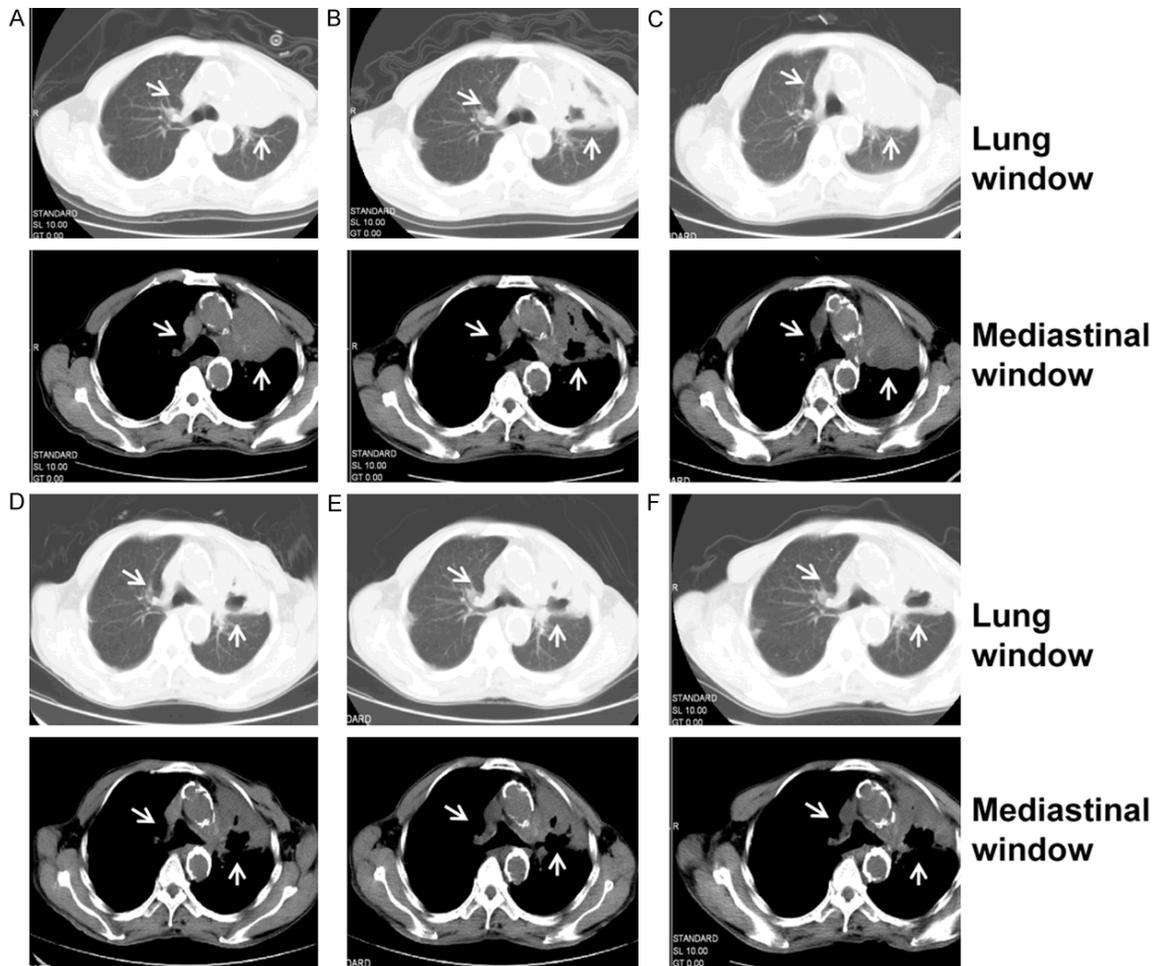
CT scans. (A) Baseline CT images revealed multiple lymph node metastases around the region of aorticopulmonary window and left hilar. (B) CT scan showed partial response after everolimus treatment for one month. (C) CT scan showed progressive disease after everolimus treatment for five months. (D) CT scan showed partial response after everolimus treatment for six months. CT scan showed sustained response after everolimus treatment for seven months (E) and eight months (F).
